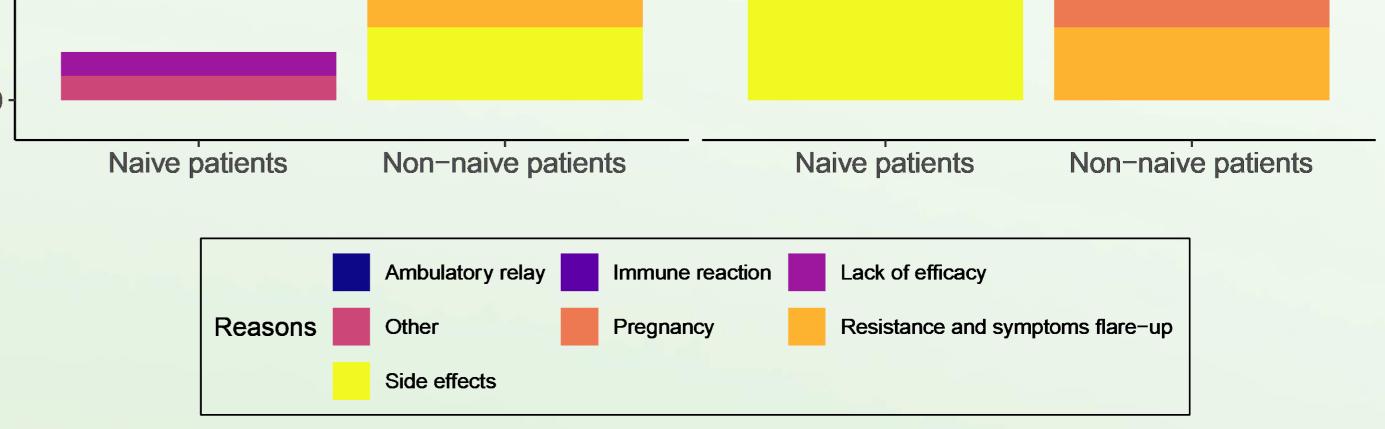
Reasons for CT-P13 discontinuation in naive and non-naive patients that switched for a different treatment of reverted back to original infliximab. OI = Original infliximab
